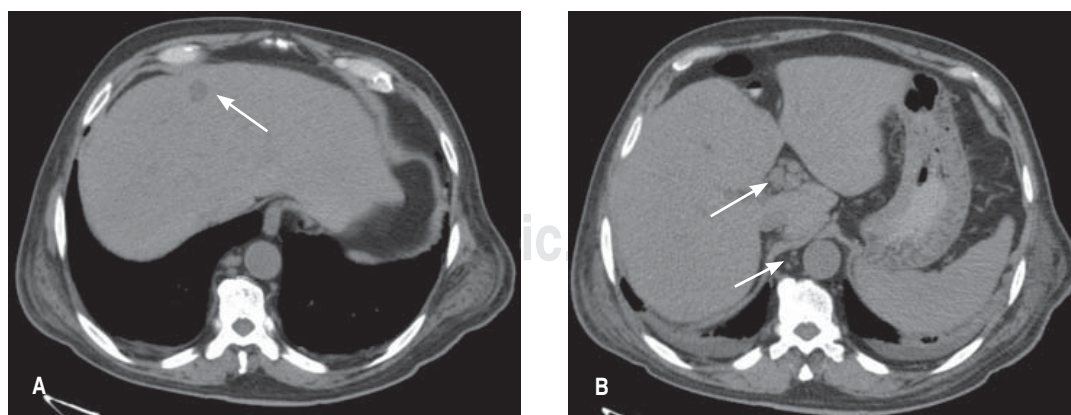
Abdominal CT scan. (A) Image of metastatic implant. (B) Nodes at the hepatic hilum and para-aortic level.
